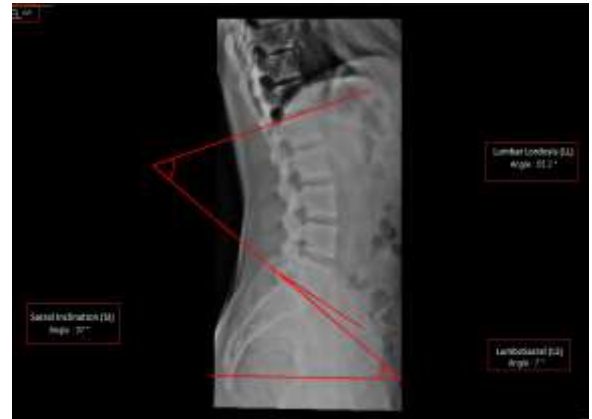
Lateral X-Ray Image For a Subject with Bilateral Shortening of The hamstrings
